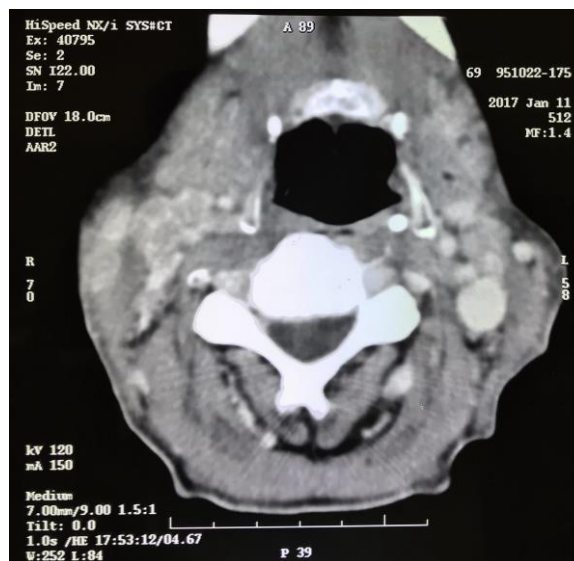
CT scan of the head and neck showed a large calcified lesion in the right parotid gland.
